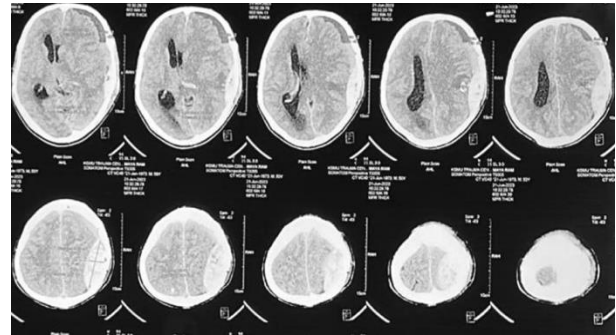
CT scan showing left hemispheric acute on chronic SDH with parietal EDH.
